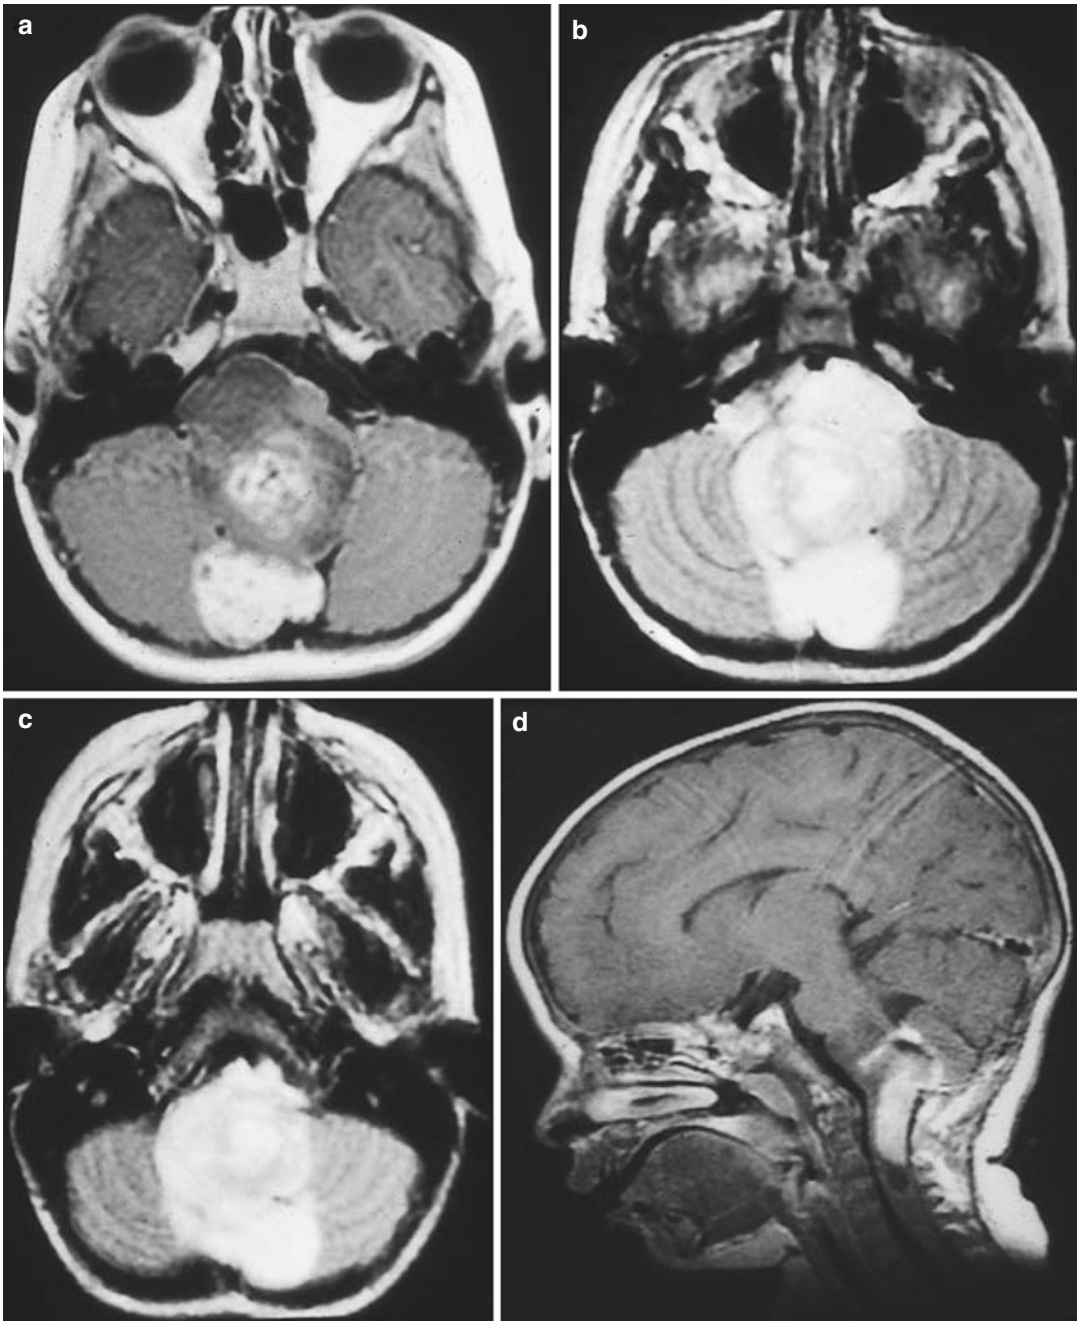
(a–d) Magnetic resonance (MR) images of dorsally exophytic tumors. (a) Axial T1-weighted image without contrast: the lesion arises from the medulla and is hypointense on T1-weighted images. (b) Axial T1-weighted image with contrast: the lesion enhances brightly with contrast, which is a typical characteristic for
